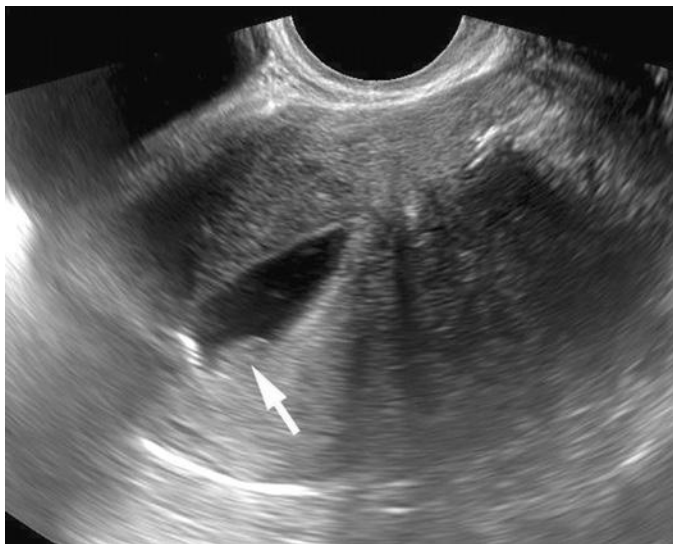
A 39-year-old woman referred for saline infusion sonohysterography (SIS) to evaluate possible filling defect seen on conventional hysterosalpingogram (HSG). Longitudinal SIS image of the uterus shows focal posterior endometrial thickening (*arrow*). The maximum diameter of the lesion is smaller than its base, consistent with a sessile polyp. Subsequent hysteroscopic removal of the lesion confirmed a 5-mm benign polyp. SIS is helpful both for demonstrating small abnormalities that may be missed on transvaginal sonography (EVS), as well as for confirming normal endometrium in the remainder of the uterine cavity. SIS can detect abnormalities missed on EVS in 14% to 24% of cases.^{6,26}
